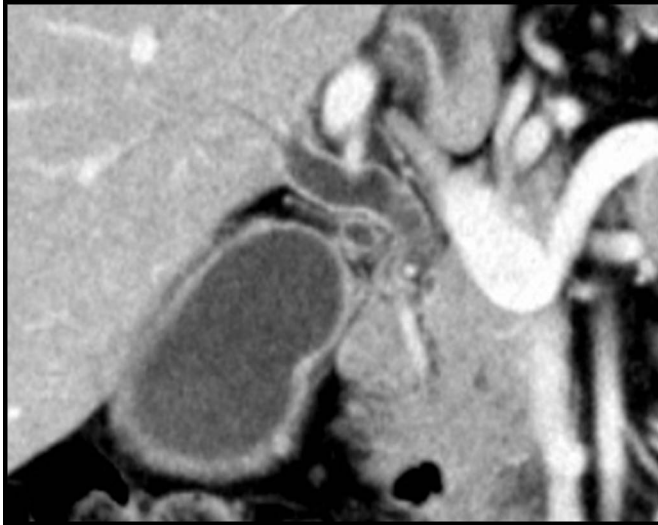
Contrast-enhanced computed tomography of the abdomen showing diffuse wall thickening, and contrast enhancement of the common bile duct and gallbladder without radio-opaque stones.
